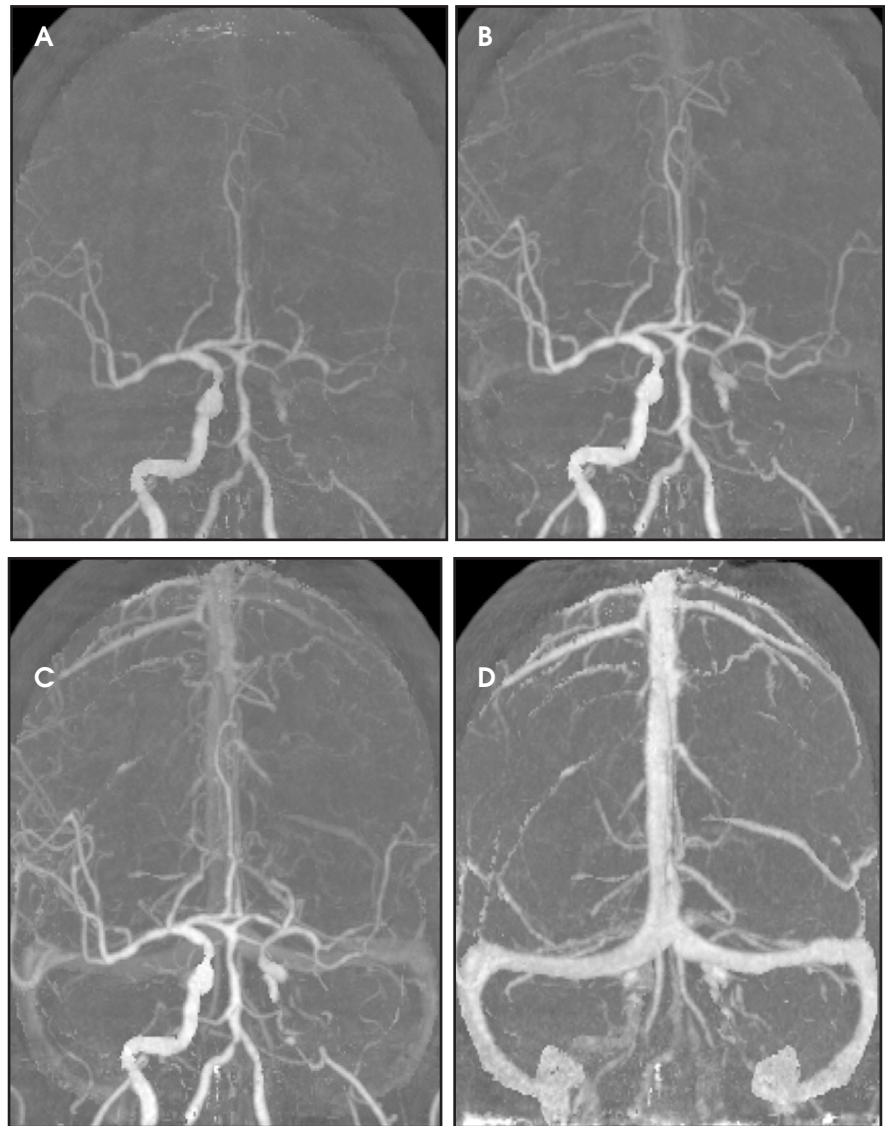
(A - D) Time resolved 4D CTA study (selected frames) extracted from whole brain CTP. Note the left ICA occlusion with progressive cross filling of the left anterior and middle cerebral artery territories and progressive retrograde filling of the left carotid siphon.
